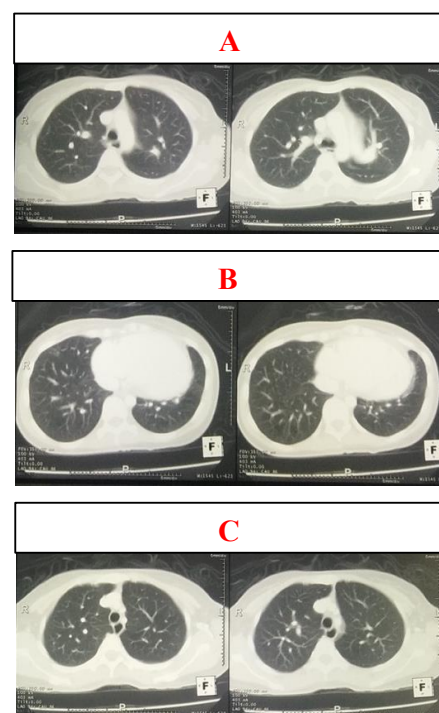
CT scan of thorax with the contrast of this patient showing (A) pulmonary hypertension; (B) cardiomegaly; (C) bilateral pulmonary fibrosis.
